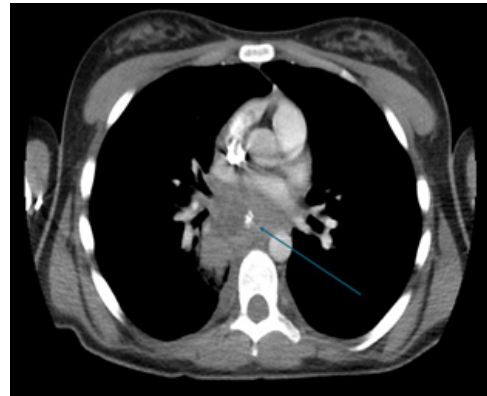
CT chest axial view of the complex cystic/necrotic and calcified mediastinal mass.
